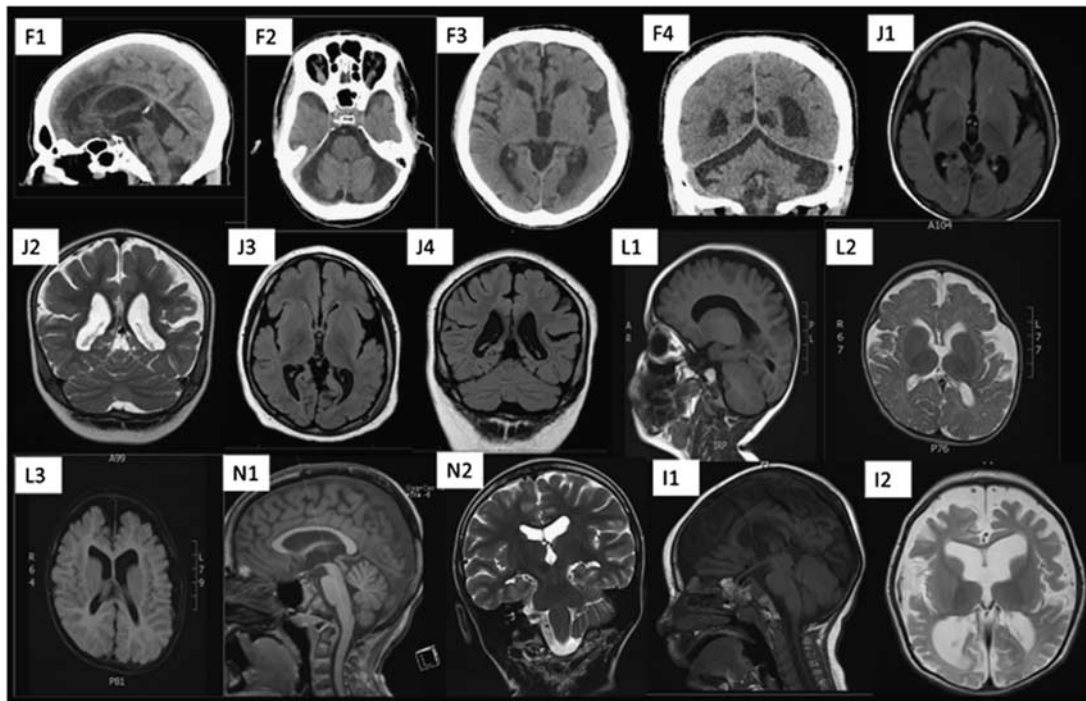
Neuroimaging of affected individuals with *CLCN4*-related condition at different ages. F1–4: CT images of individual F:IV:3, aged 66. Non-contrast multi-slice helical acquisitions, thick-slice reconstructions only. F1: sagittal midline image depicts callosal thinning, atrophic midbrain and cerebellar atrophy with prominent quadri-cerebellar cistern. F2: axial image of posterior fossa depicting cerebellar vermian atrophy with increased caliber of the adjacent CSF spaces. F3: axial image depicting prominent Sylvian fissures and increased caliber of lateral and third ventricles with surrounding atrophic change and evidence of a right frontal infarct. F4: coronal image showing disproportionate cerebellar atrophy and prominence of the adjacent CSF spaces. J1–6: MRI images of individual J:III:2 aged 4 and 8. J1: Axial FLAIR image from individual J:III:2, aged 4, depicting enlarged Sylvian fissures secondary to surrounding volume loss, particularly affecting the frontal lobes. J2: coronal T2 weighted image from individual J:III:2 aged 4 depicting generalized white matter volume loss. J3 Axial FLAIR image from individual J:III:2 aged 8 demonstrating periventricular leukomalacia. J4: coronal FLAIR image from individual J:III:2 aged 8. Images depict that despite interval progression of myelination between the ages of 4 and 8, there is still significantly delayed myelination involving the anterior frontal, posterior parietal and temporal lobes. The corpus callosum is normally formed but attenuated. There is pronounced global volume loss, preferentially affecting the white matter. Prominent perivascular spaces are seen bilaterally. L1–3: MRI images from family L proband at four months of age. Diffuse cortical hypoplasia with resultant prominence of the extra-axial CSF spaces and thinning of the corpus callosum without other morphological abnormalities. Myelination is otherwise grossly normal. N1–2 MRI images from proband from family N aged 10. N1: sagittal T1 weighted midline image showing dilated third ventricle. N2: Coronal T2 weighted image showing dilated third ventricle. I1–2: images from proband from family I aged 13 months. I1: sagittal T1 weighted midline image showing dilated lateral ventricles. I2: axial T2 weighted image showing volume loss, periventricular leukomalacia and dilated ventricles. CSF, cerebrospinal fluid; MRI, magnetic resonance imaging.
